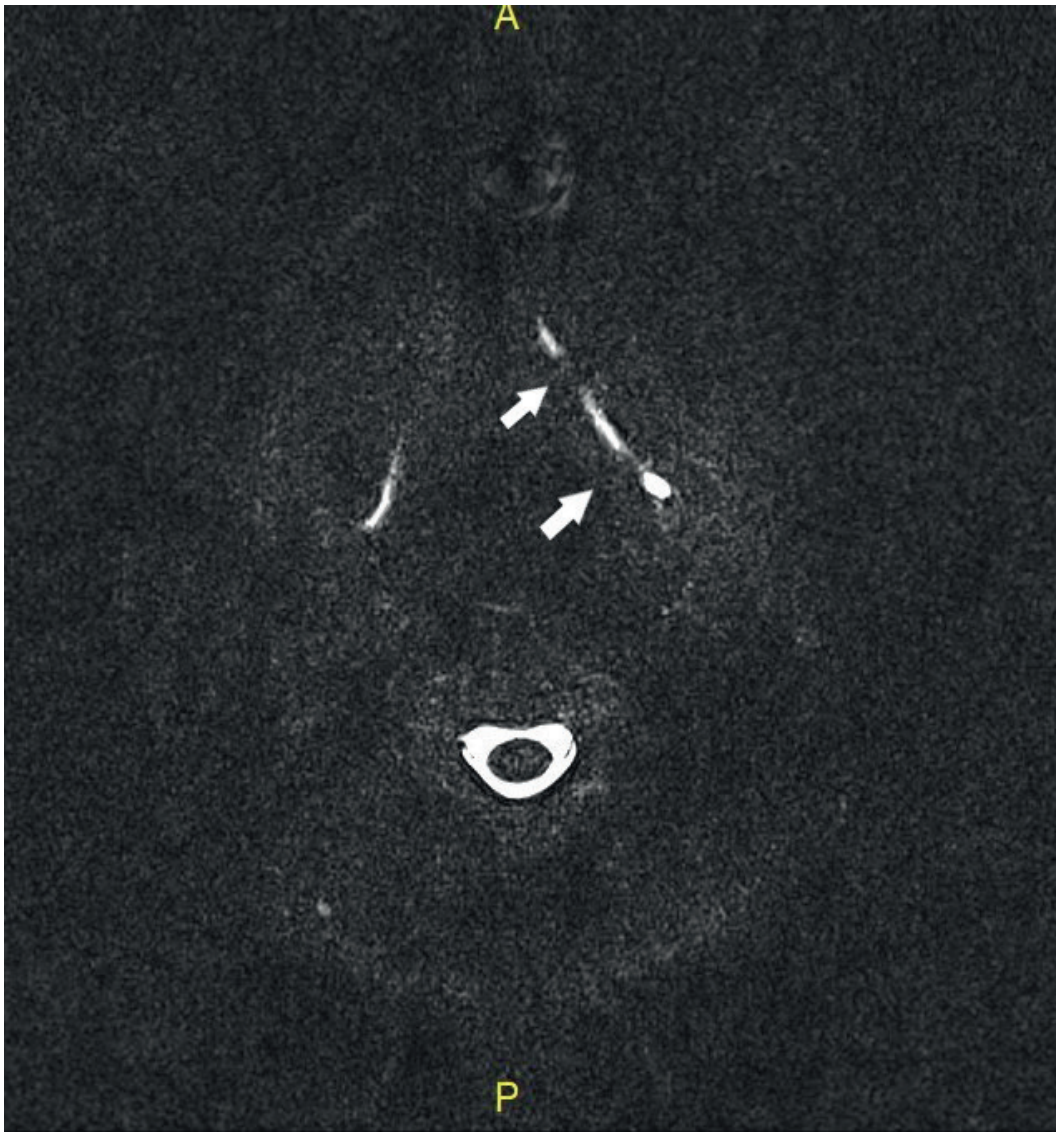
MRI sialography showing dilation of the left Wharton's duct with two stones in the middle and its distal aspect
